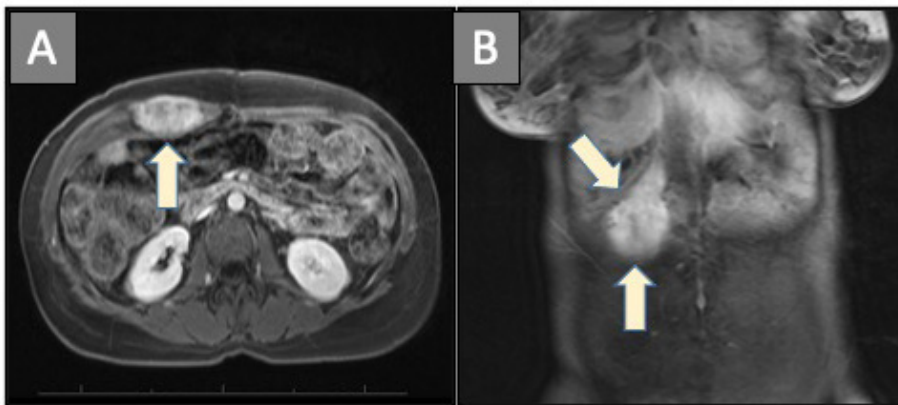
(A) Axial and (B) coronal delayed post contrast T1 magnetic resonance imaging demonstrates an irregularly shaped enhancing mass within the right upper rectus abdominis muscle (arrows).
